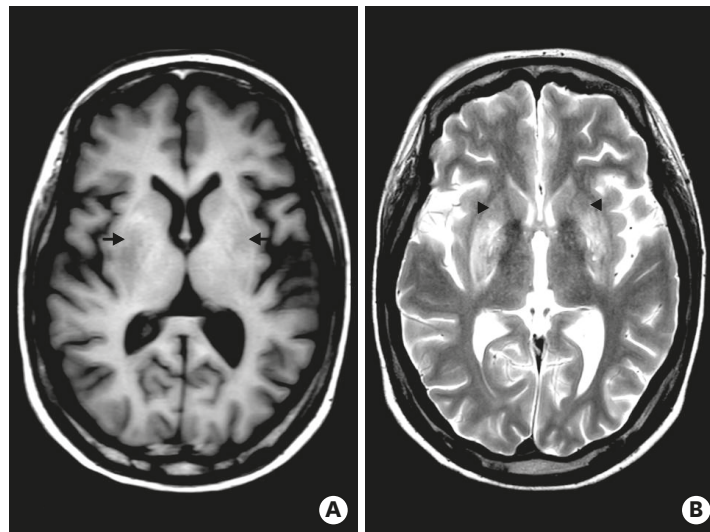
(A) Follow-up T1-weighted images of brain magnetic resonance imaging showing decreased hyperintensities at bilateral globus pallidus and putamen (black arrows). (B) Corresponding T2-weighted image showing decreased hyperintensities (arrowheads).
